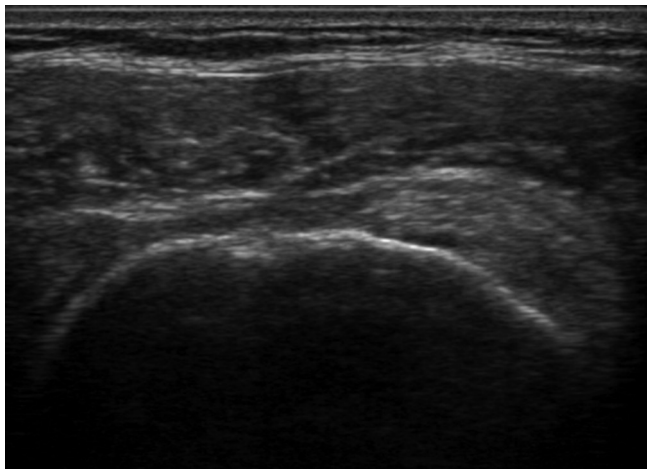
Partial tear of supraspinatus on high-resolution ultrasonography
